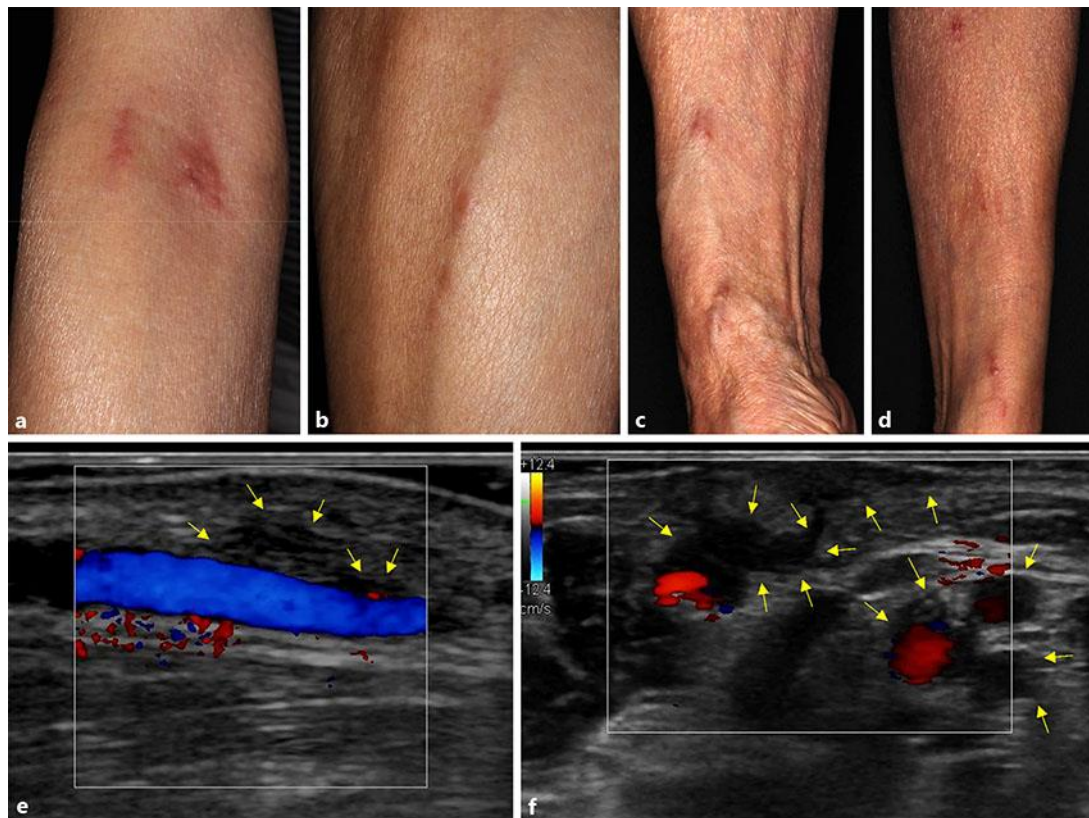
Multiple papules and nodules along with the superficial venous lines on the flexor (a) and extensor aspects of the right forearm (b). The newly developed lesions along the peripheral cephalic veins of the right (c) and (d) left forearms. Transcutaneous ultrasonography showing hypoechoic masses that surround the superficial vein, as indicated by yellow arrows (e, f).
